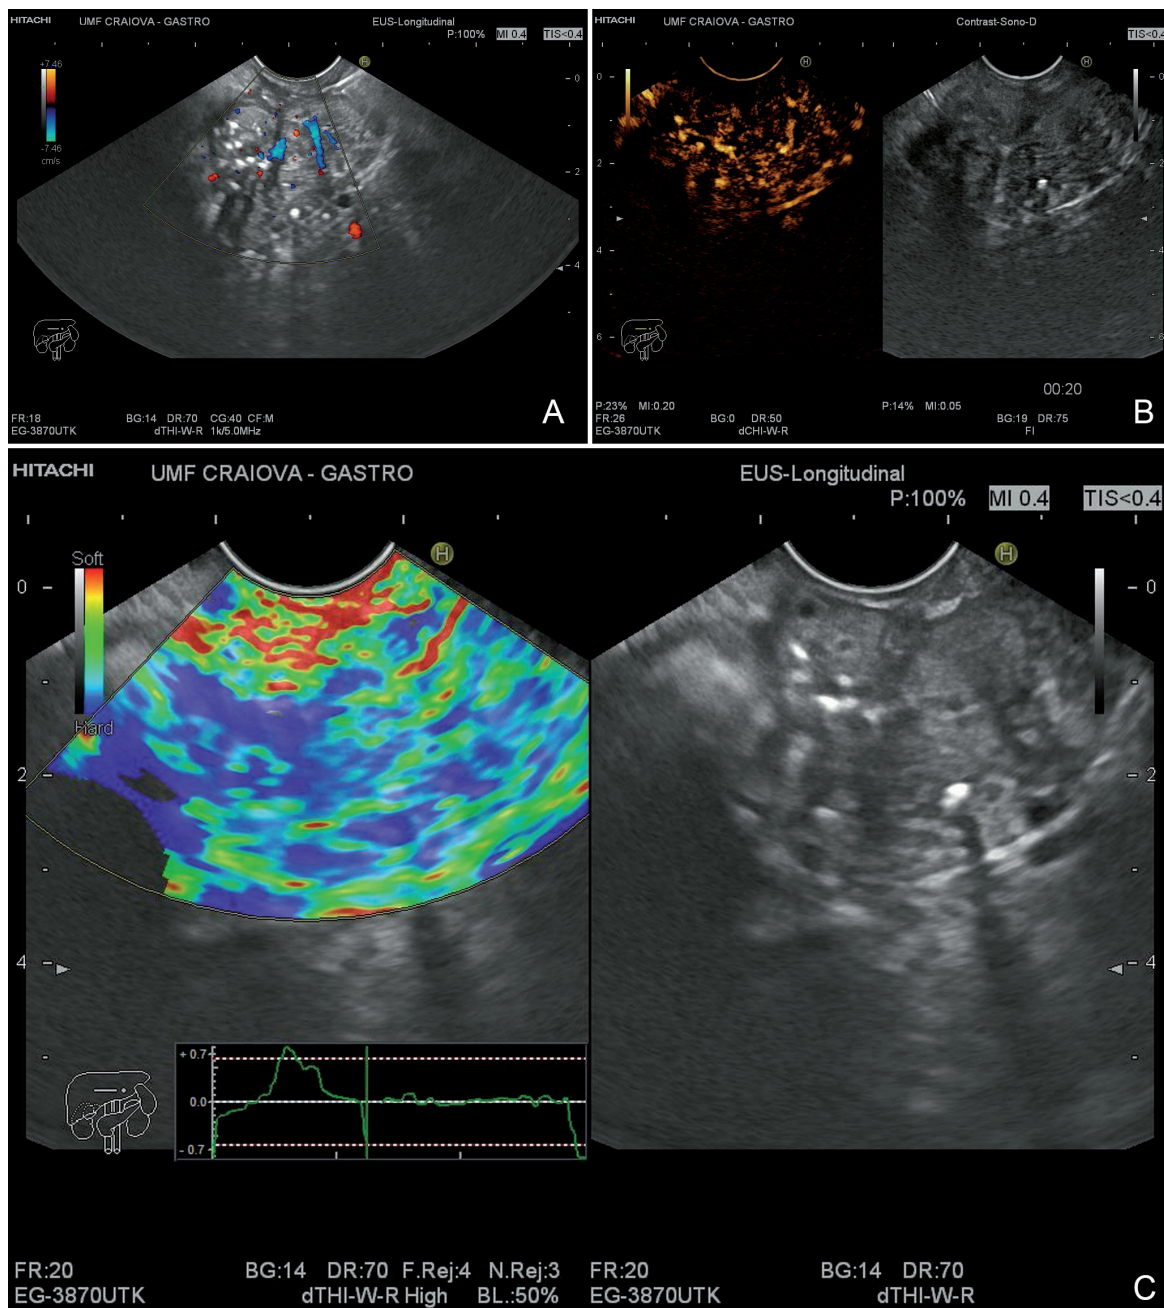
Multimodal imaging of chronic pancreatitis. A. EUS – Doppler imaging. B. Contrast-enhanced ultrasound imaging. C. EUS-E imaging with strain histogram.
